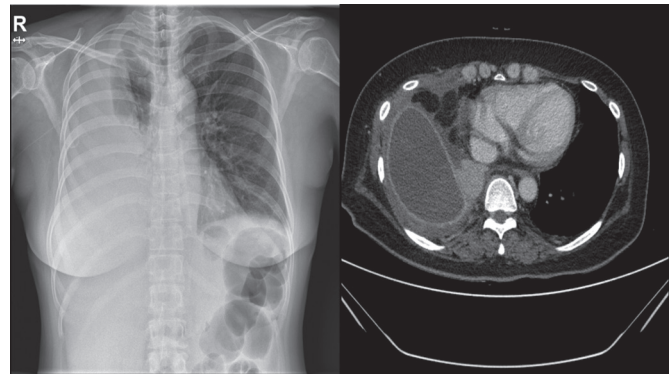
Chest radiograph and chest computed tomography (CT) scan on admission.
